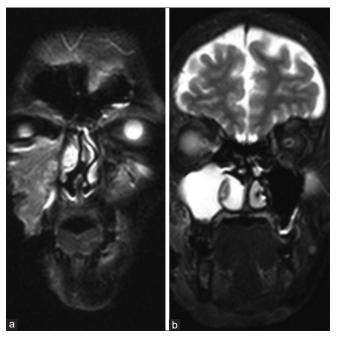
(a): MRI of face showing altered signal intensity lesion over the right cheek involving skin and subcutaneous tissue; isointense on T2 weighted imaging with patchy areas of hyperintensity at periphery. (b): MRI showing mucosal disease in right maxillary sinus
